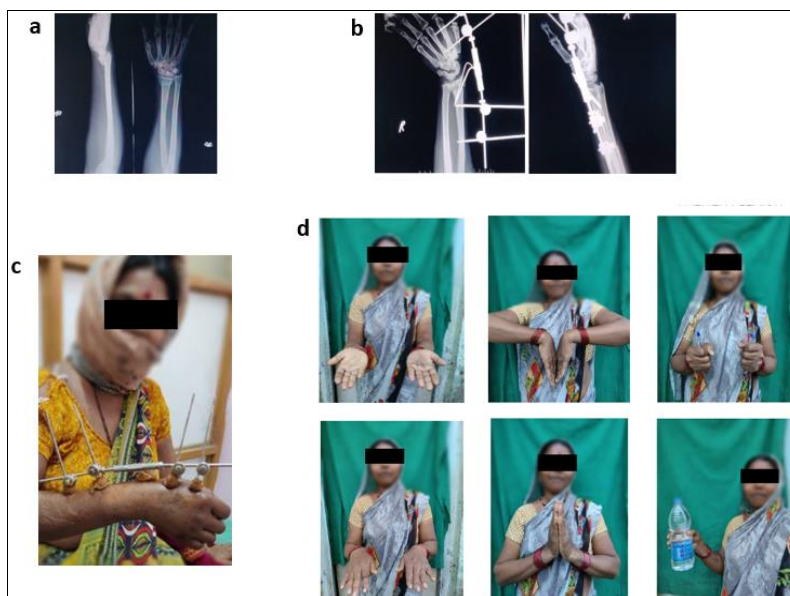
Case 1: a. Pre-operative X-Rays. b. Post-operative X-Rays. c. Post-operative clinical photo. d. Supination, Palmer Flexion and Grip Strength (Up, left to right), Pronation, Dorsi Flexion and Grip Strength (Down, left to right)
